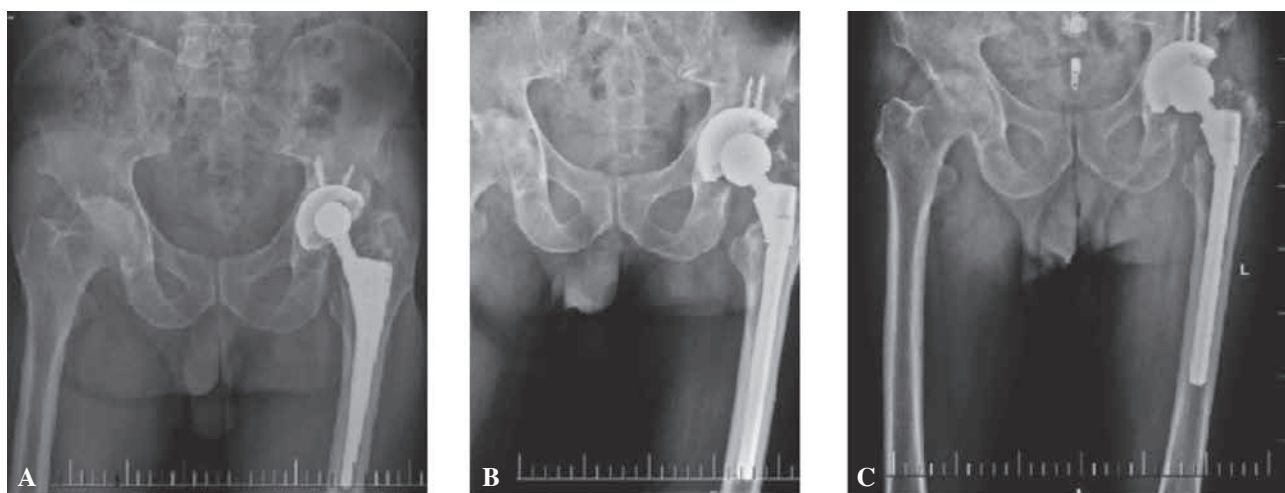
Preoperative (A), postoperative (B), and follow-up AP (C) X-rays of the patient following revision THA via previous antero-lateral approach.
